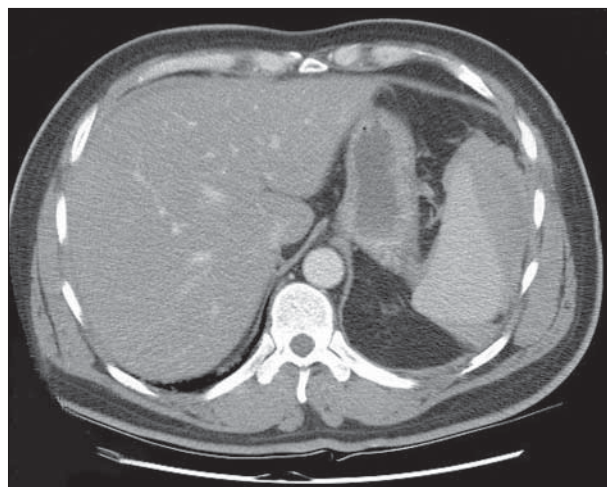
Computed tomography of the abdomen demonstrating splenic hematoma.
